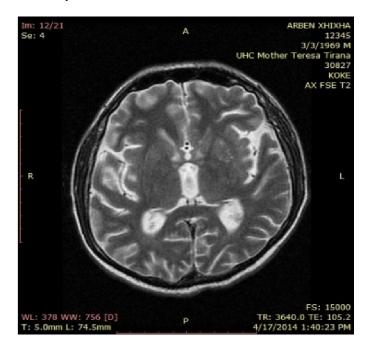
Imaging of brain MRI four weeks after treatment
